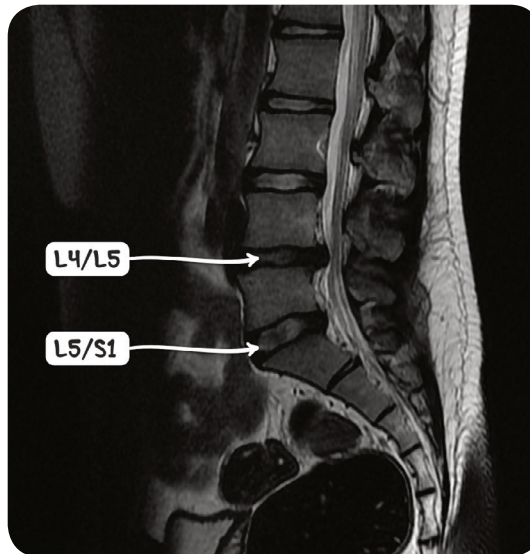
An MRI scan of the spine in the sagittal plane demonstrating protrusion of the L4/L5 and L5/S1 intervertebral discs.
